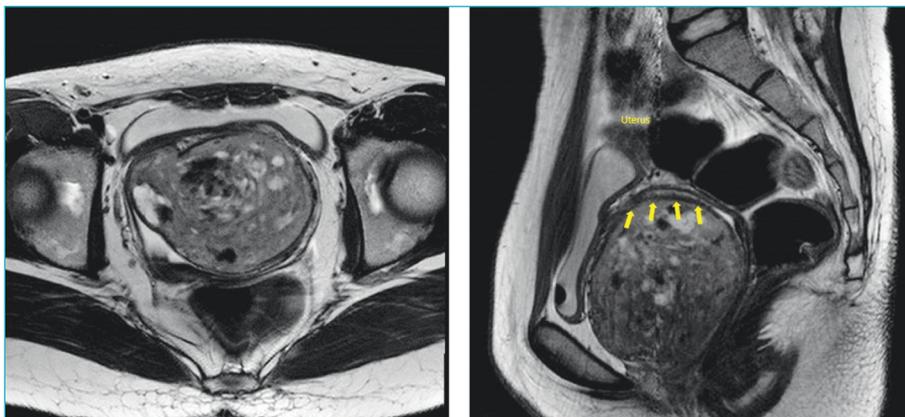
T2-weighted magnetic resonance images (A: coronal view, B: sagittal view) show well demarcated mass with heterogeneous signal intensity with multifocal small cystic changes. Arrows are indicating that the mass was compressed the vagina and uterus.
